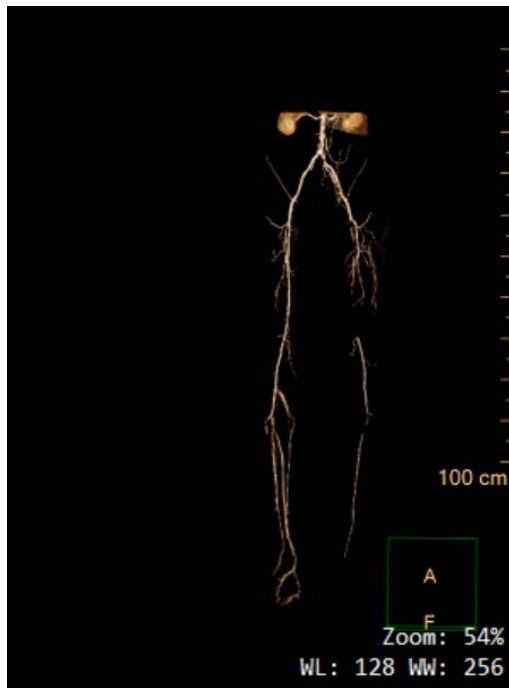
Computed Tomography Angiography (CTA)
